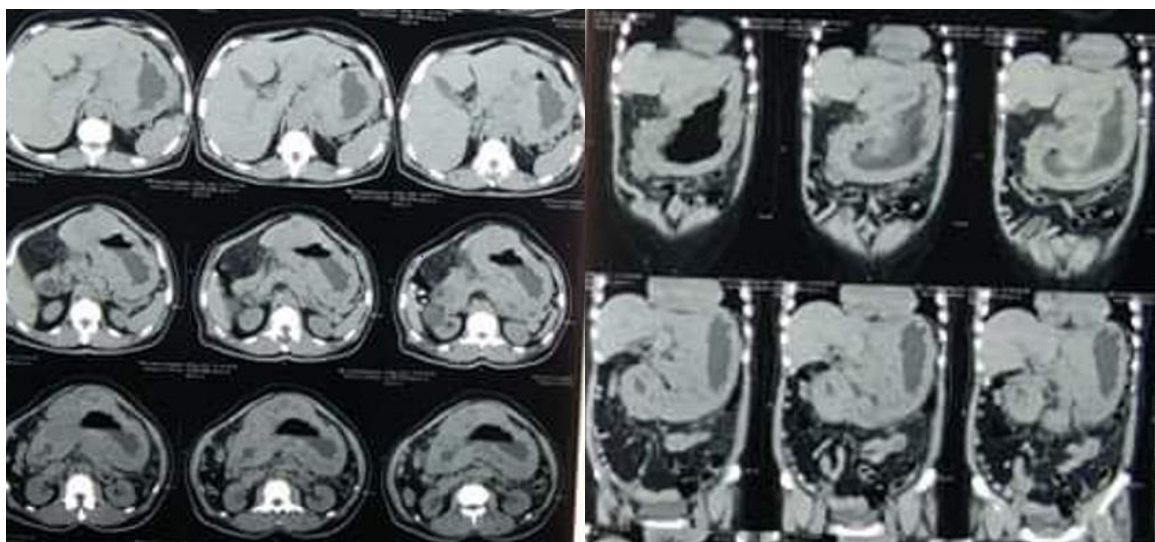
CT scan of whole abdomen showed infiltrative gastric lymphoma with abdominal lymphadenopathy
